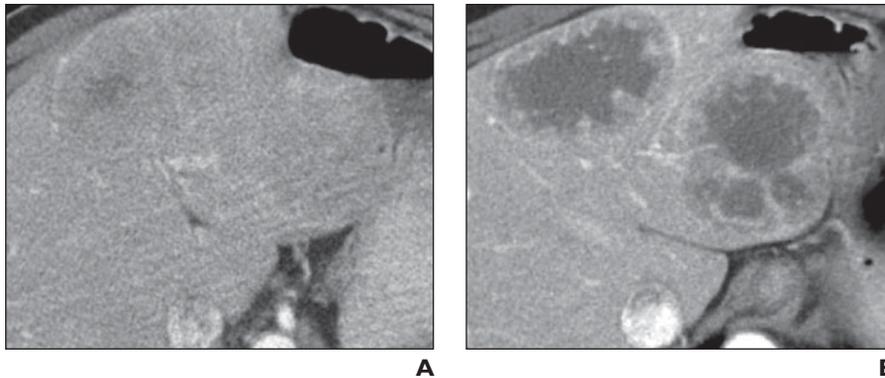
64-year-old man with metastatic renal cell carcinoma (RCC). Contrast-enhanced CT (CECT) depicts two RCC metastases to liver before and after initiation of sorafenib therapy.
